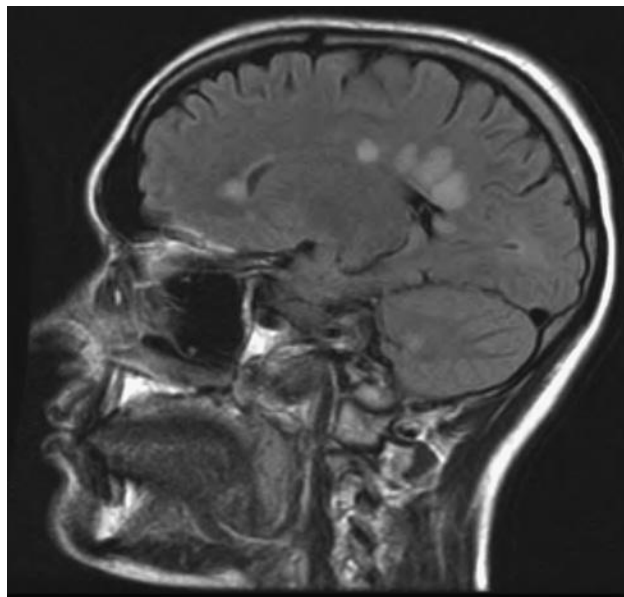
MRI of brain from a patient with multiple sclerosis in sagittal view (as in Figure 1-9). Multiple plaques (light areas) where neurons have lost their myelin coating are visible.
